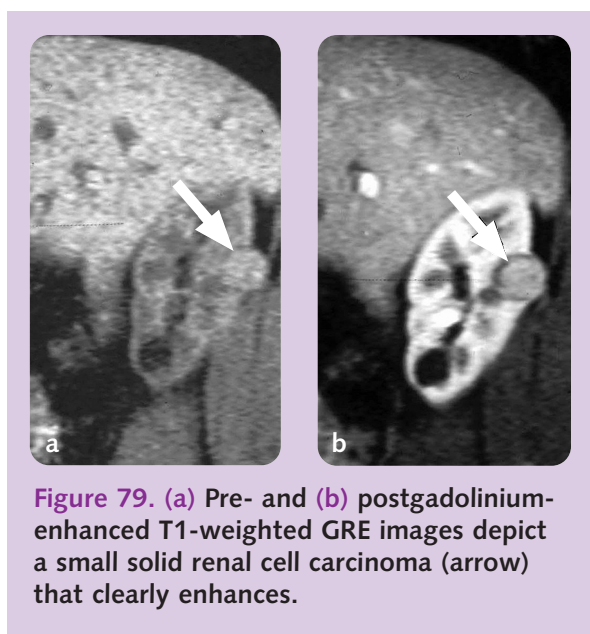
(a) Pre- and (b) postgadolinium-enhanced T1-weighted GRE images depict a small solid renal cell carcinoma (arrow) that clearly enhances.
